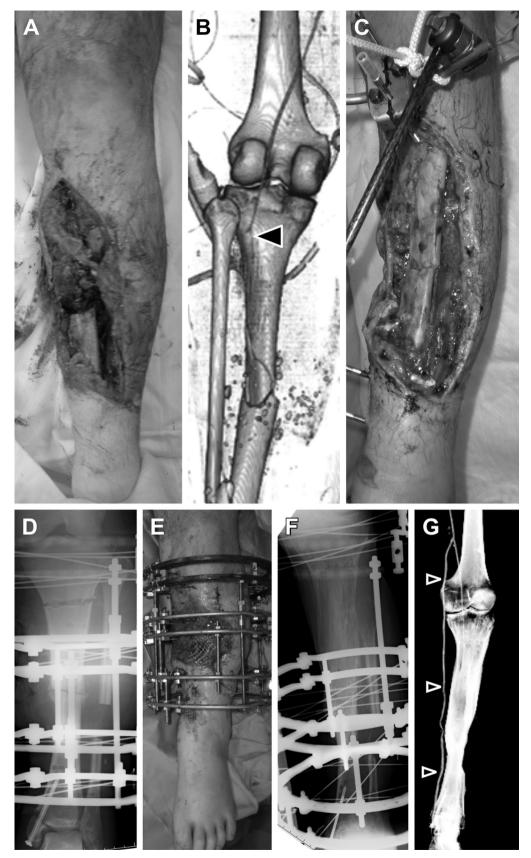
(A) Case 1: Left Gustilo—Anderson type IIIC opentibial fracture. (B) Case 1: Computed tomography angiography on the day of admission demonstrated a disruption of the popliteal artery (black arrow). The artery was repaired by a saphenous vein graft. (C) Case 1: A major part of the tibia was exposed because the free vascularized soft-tissue underwent necrosis. (D, E) Case 1: The bone gap and soft-tissue defects were closed at the end of shortening. An Ilizarov frame was applied and osteotomy of the proximal tibia was performed for subsequent lengthening. (F) Case 1: The tibia was lengthened by 10 cm. (G) Case 1: The vein graft at the site of the shortening and lengthening was contrasted without any problem in computed tomography angiography (white arrows).
